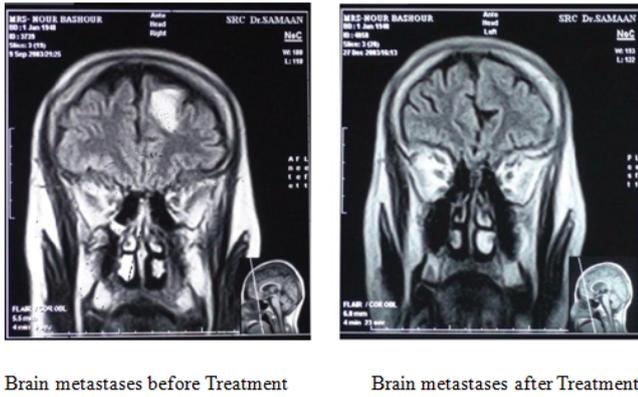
Brain Metastases before treatment and after treatment on MRI.
